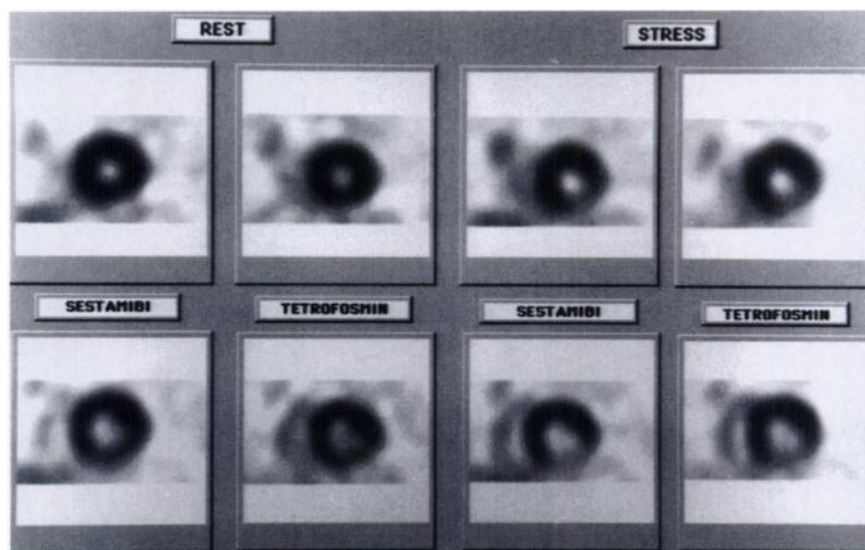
Comparative display of short-axis SPECT images obtained 60 min after administration of sestamibi and tetrofosmin at rest and during dipyridamole stress in a patient with suspected CAD. The upper images represent midventricular and the lower images basal myocardial slices. Similarities of defect extent, intensity and severity were demonstrated.
